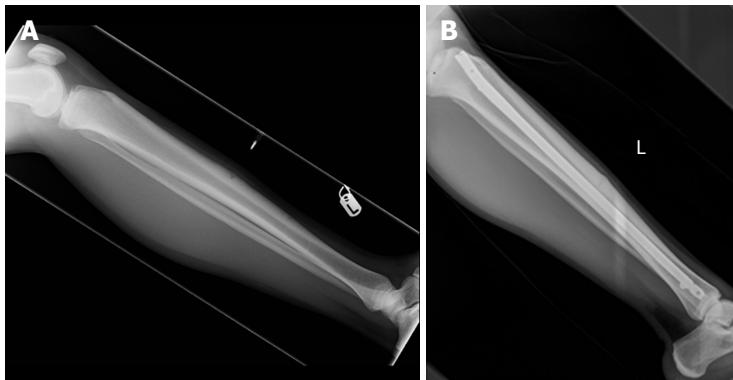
The management of an anterior tibial diaphyseal stress fracture. A: Pre-operative lateral radiograph; B: Post-operative lateral radiograph.
